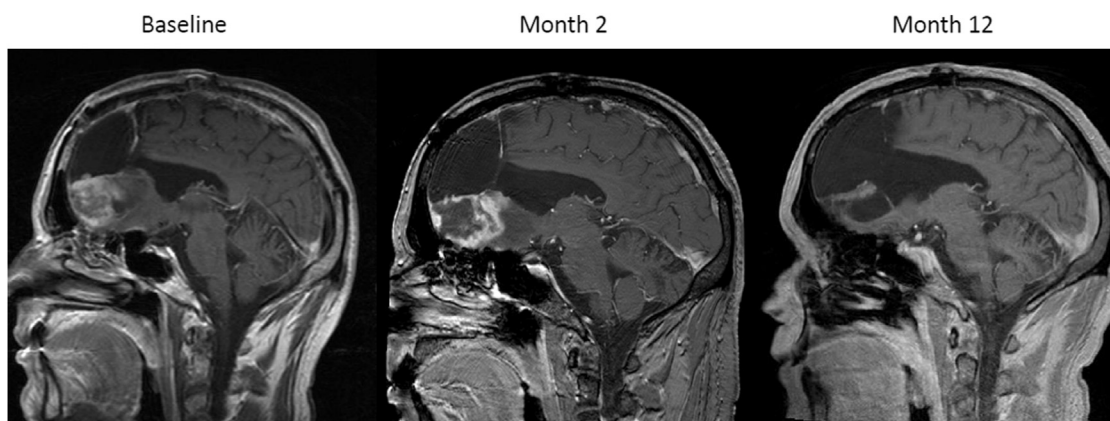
Exemplary T1-weighted images after contrast agent administration of a 48-year-old male with prior grade II astrocytoma, which transformed to glioblastoma (based on tissue biopsy). The subject progressed after receiving chemoradiotherapy and adjuvant temozolomide (3 courses) and subsequently responded to NovoTTF Therapy (PR at 12 months) and remained stable for an additional 20 months on TTFIELDS.
